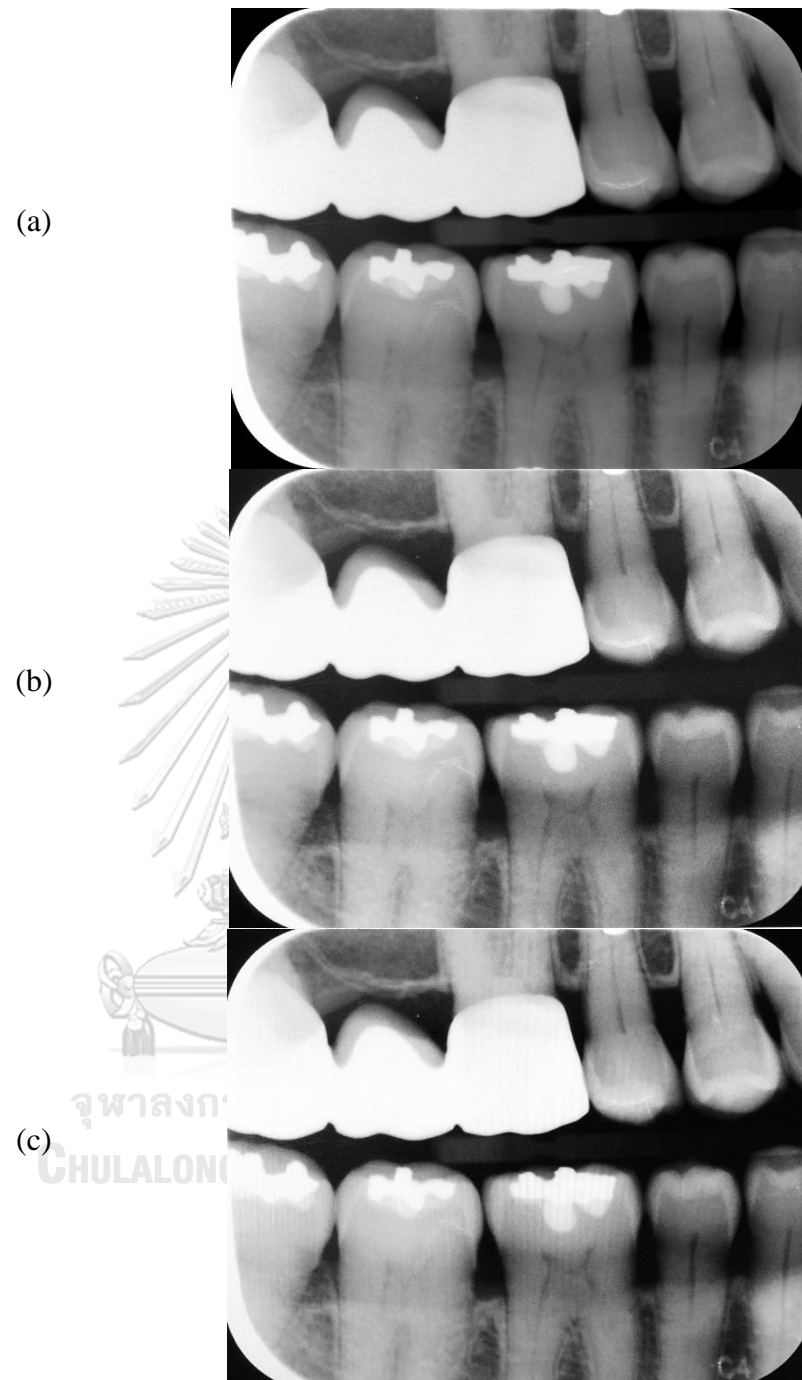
shows three images of sampled digital bitewing radiograph from three different image acquiring methods. ((a) image directly exported from PACS software, (b) image captured from a medical-grade display, (c) image captured from a common display)
